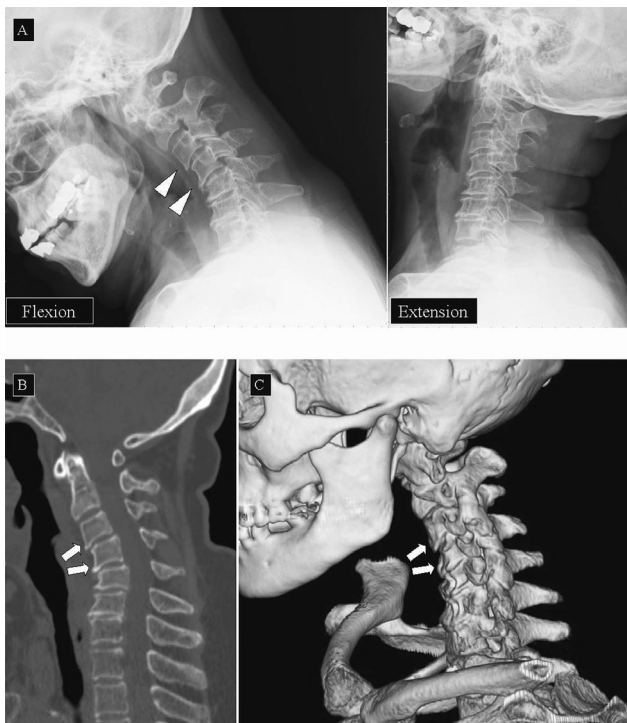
A: Cervical flexion and extension radiographs. B: Bone window (W 2,000, C 350) on sagittal computed tomography. C: Volume rendering on computed tomography.
